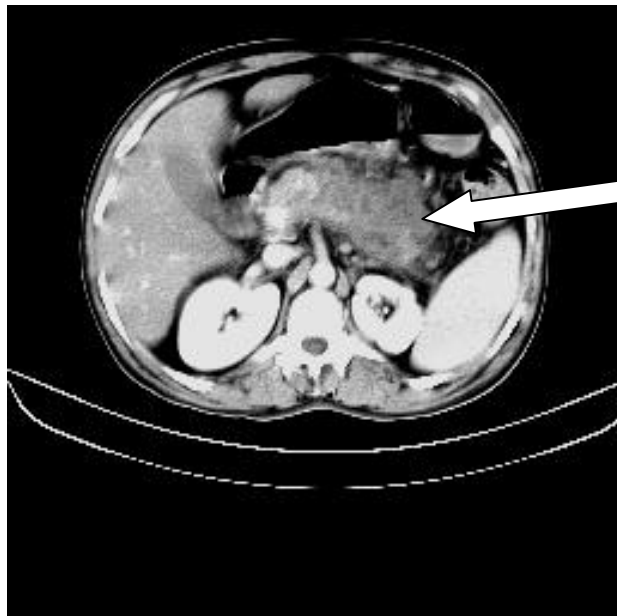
FIGURE # 13 : CONTRAST ENHANCED CT ABDOMEN AXIAL SECTIONS SHOWING DIFFUSELY BULKY PANCREAS WITH NECROTIC COMPONENTS WITHIN(SMALL ARROW), LOCULATED COLLECTIONS (ARROWHEAD), IRREGULAR MASS LESION INVOLVING PANCREATIC HEAD(ARROW) WITH PERIPANCREATIC FAT STRANDINGS.
